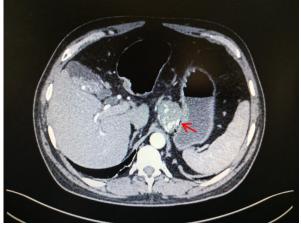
CT scan showing a large GE mass with significant luminal compression and calcification. Also the gall bladder showed stones and slugde and was mildly thickened.
